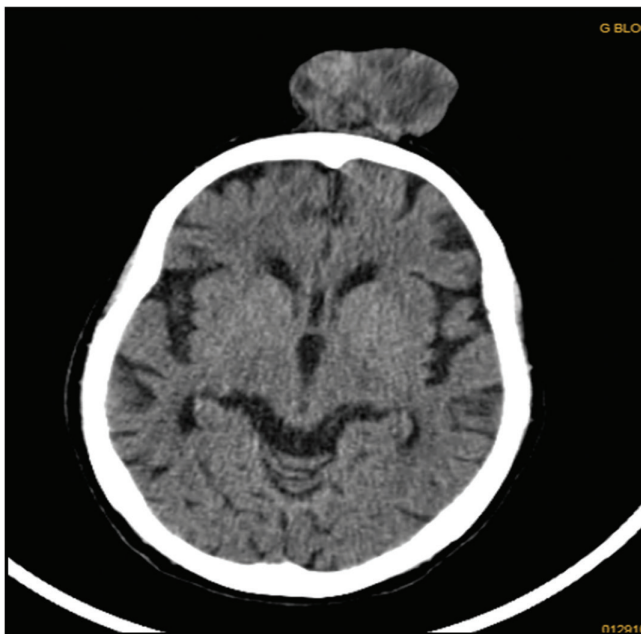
Case 2 CT scan of scalp lesion
